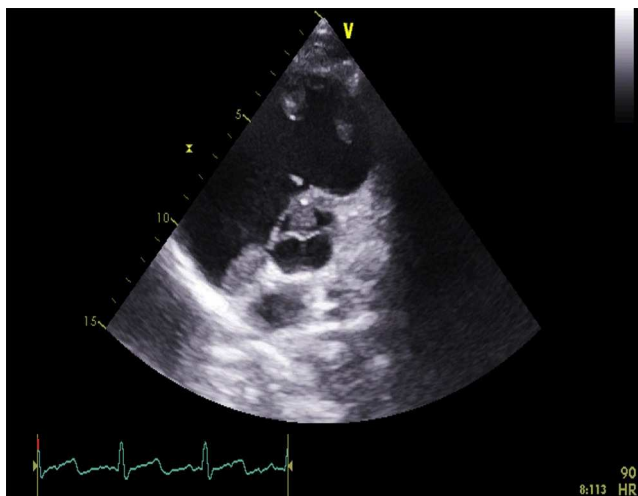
Apical 5-chamber echocardiogram view showing thrombi in the right ventricle.
